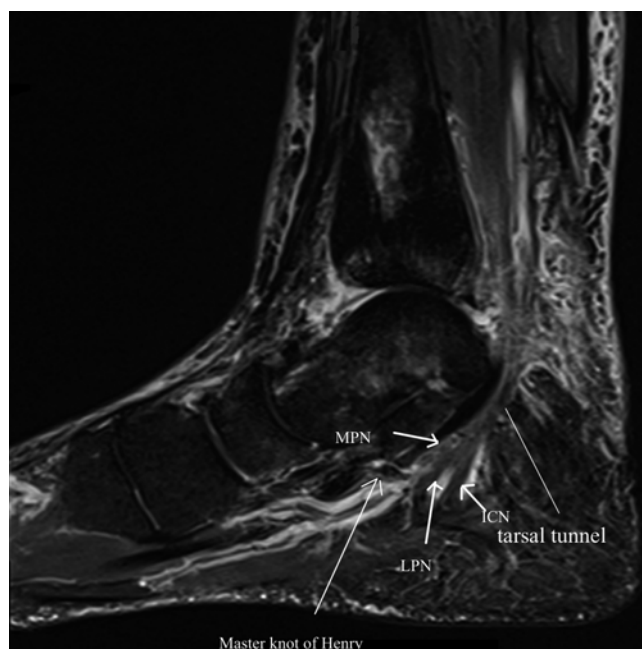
STIR sagittal MRI of the medial malleolus showing the proximal and distal tarsal tunnels and the knot of Henry. MPN medial plantar nerve, LPN lateral plantar nerve, ICN inferior plantar nerve (Image courtesy of Andrea Trescot, MD)
